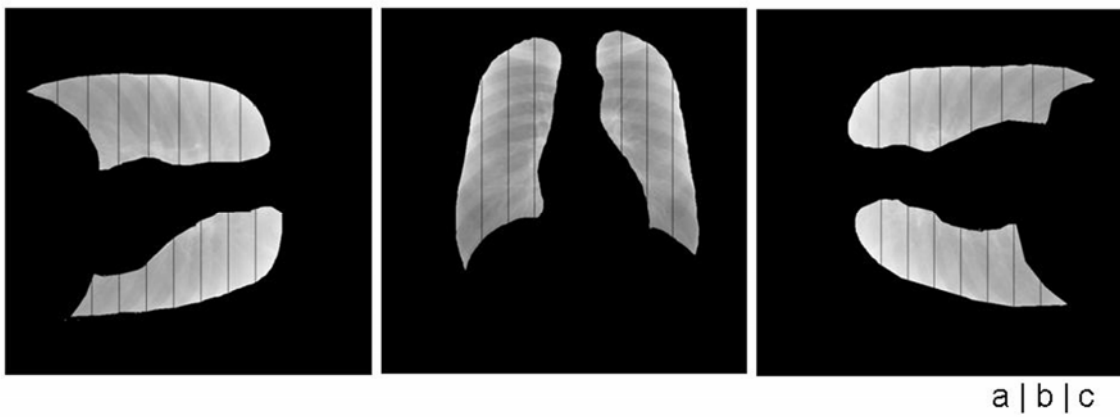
Dynamic chest radiographs were divided vertically into eight zones per lung. (a) Left decubitus position. (b) PA standing position. (c) Right decubitus position.
